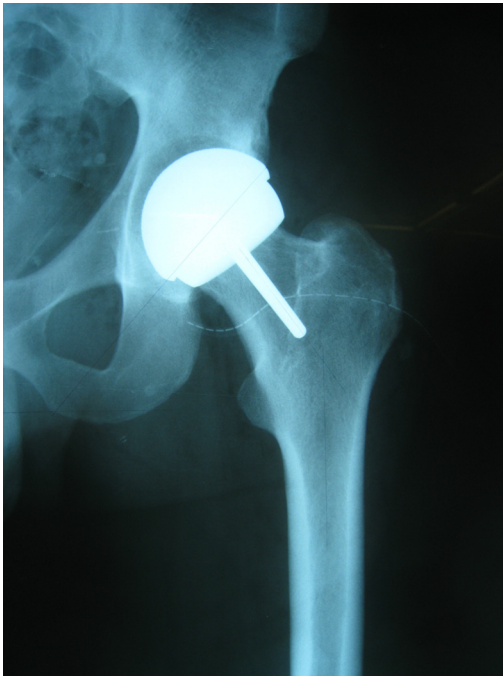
Postoperative AP X-ray of the left hip. The orientation of the acetabular cup is good (frontal plane inclination 41°) but there is a large gap.
